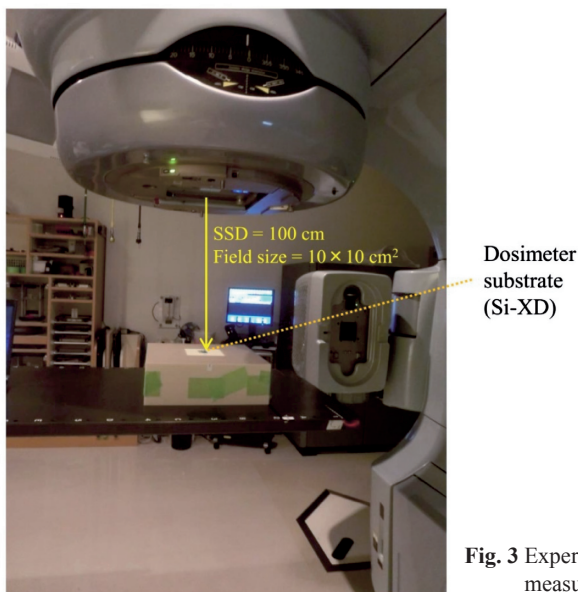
Experimental setup for measuring doses using the substrate. The dose measurements were performed using 4 and 10 MV X-ray beams.
